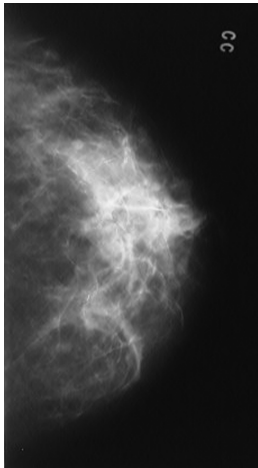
A denoised image of the X-ray mammogram (shown in Fig. 2.23) reconstructed after soft thresholding coefficients in the wavelet decomposition domain.
